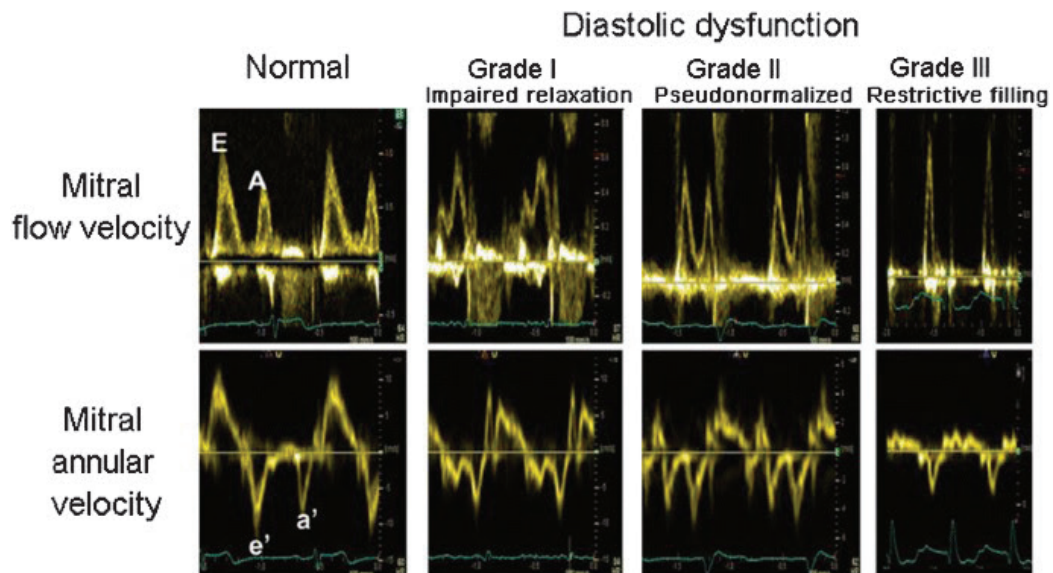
Doppler tracing in different stages of diastolic dysfunction.
